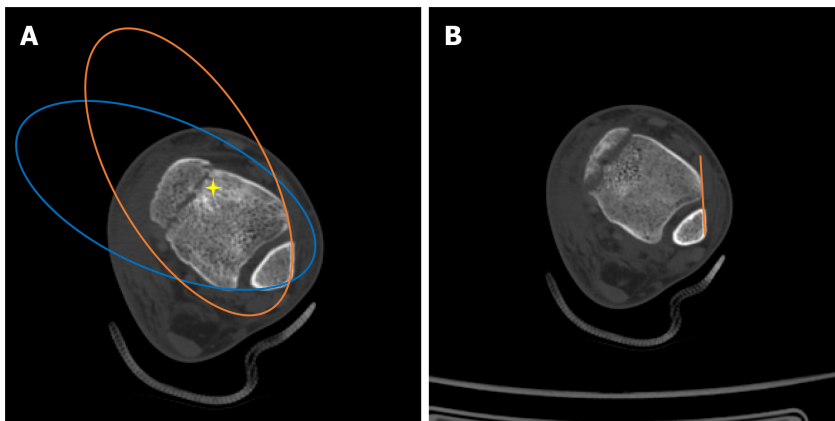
Assessment of inferior tibiofibular syndesmosis in computed tomography scans. A: Bartoniček *et al*[6]'s evaluation method: The anterior aspect of the distal fibula and tibia was continuous, similar to the posterior aspect, "star" area of higher density of the subchondral cancellous bone; B: The distance between the Tillaux-Chaput tubercle and Gifford and Lutz[7]'s tibiofibular line did not exceed 2 mm at the level of 10 mm superior to the tibial plafond.
